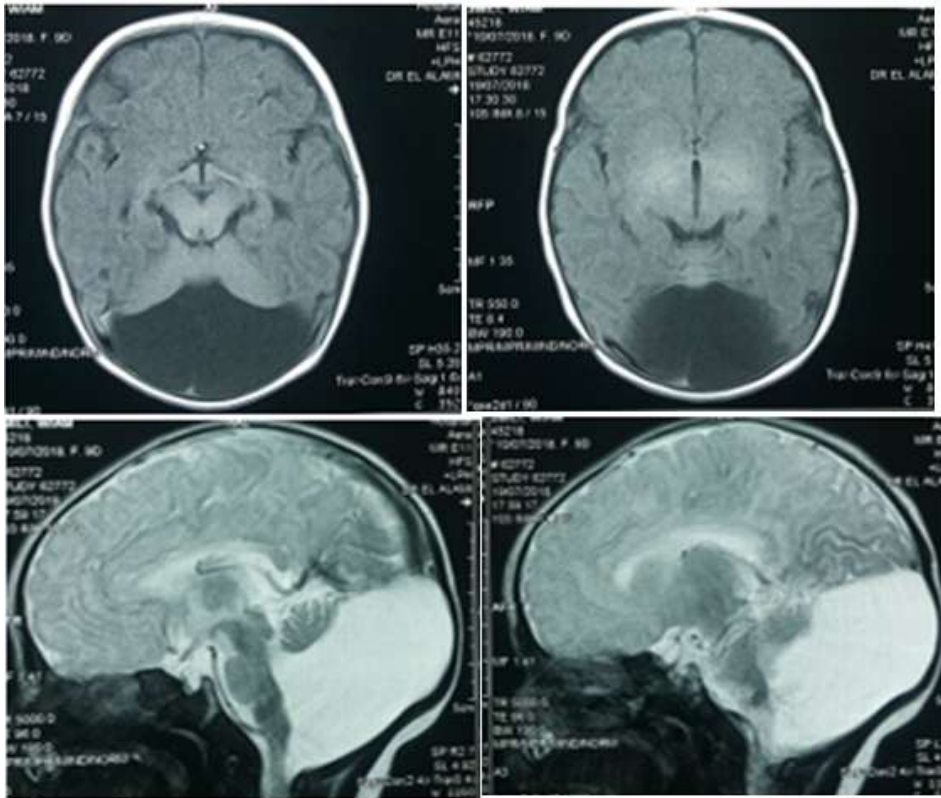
magnetic resonance imaging MRI axial T1, and sagittal T2 flair showed an atrophy of the cerebellar hemispheres, hypoplasia of the vermis, and an enlargement of the fourth ventricle
